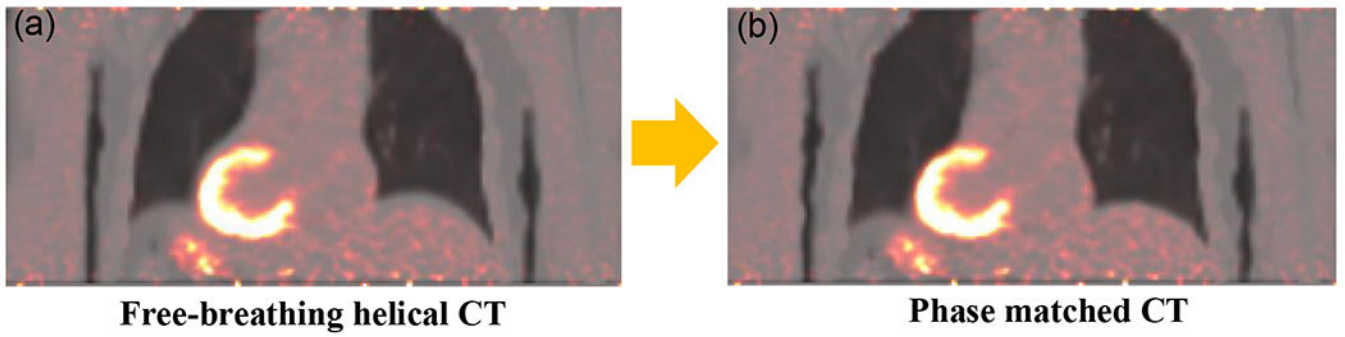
Gated PET reconstructions at end-inspiration phase from Deep Clustering method superimposed with (a) free-breathing helical CT and (b) phase matched CT.
